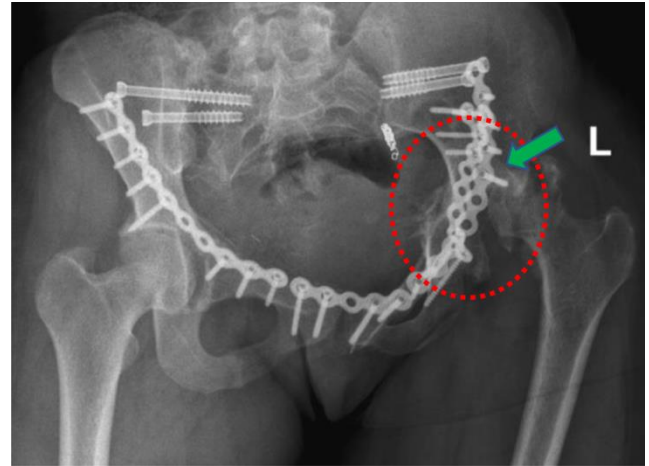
Figure XIV (Case two): Anteroposterior pelvic X-ray taken at 6-months post injury- showing healed bilateral superior pubic ramii fractures and right inferior pubic ramus fracture. On the left side the femoral head is noted to have undergone avascular necrosis (red dotted circle) and had subluxated posteriorly (green arrow).
